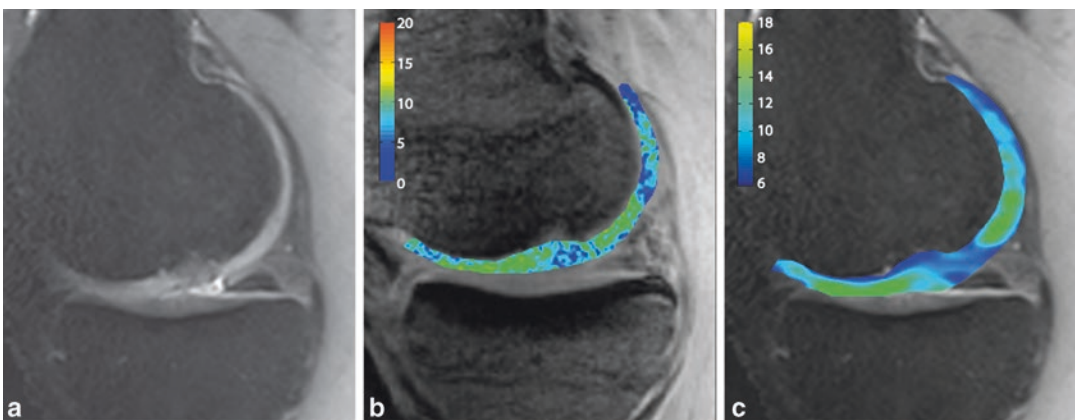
A 30-year-old patient after microfracturing in the medial femoral condyle was examined using high-resolution (a) morphological, (b) gagCEST, and (c) ^{23}Na MR imaging. Color bars on (b) and (c) represent MTR asym values summed over offsets from 0 to 1.3 ppm
